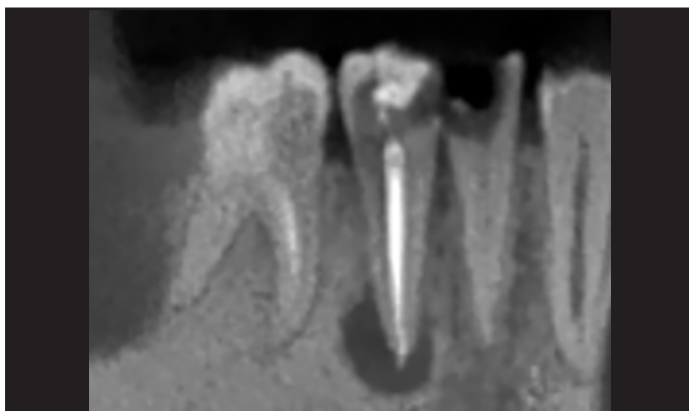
Extrusion of obturation material beyond the radiographic root apex
